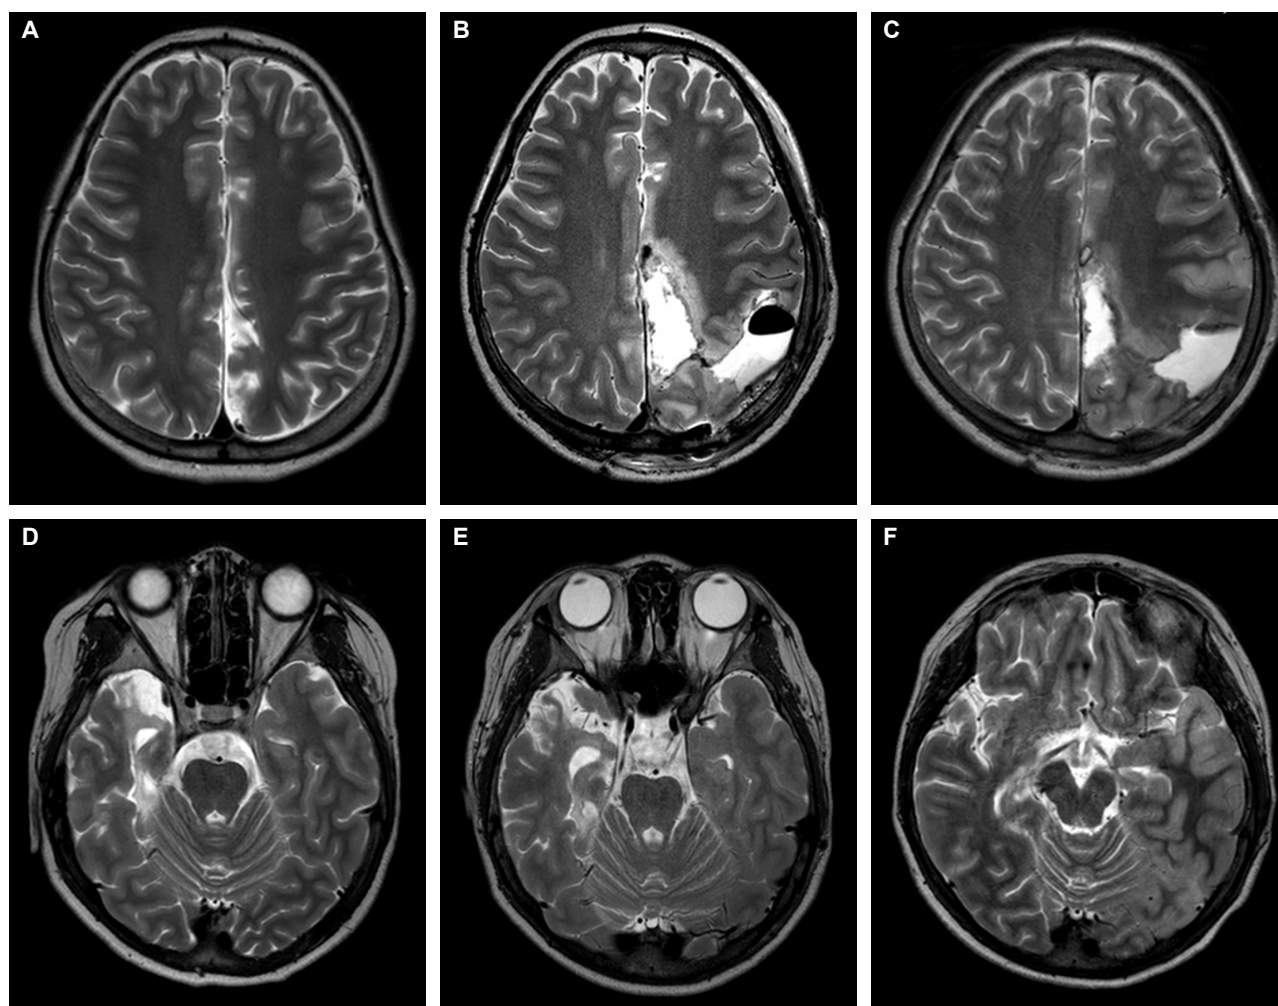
Axial T2-weighted MR images acquired before neurosurgery (A, B) show focal encephalomalacia in the right temporal and left parietal lobes, suggestive of sequelae of previous insult. Axial T2-weighted MR images acquired on the third postoperative day (C, D) showed swelling and increased subdural fluid collection near the resection margin. On postoperative day 10, axial T2-weighted MR images (E, F) showed hyperintensity in the left temporoparietal region not adjacent to the resection margin, suggestive of cerebral venous infarction or encephalitic change.
